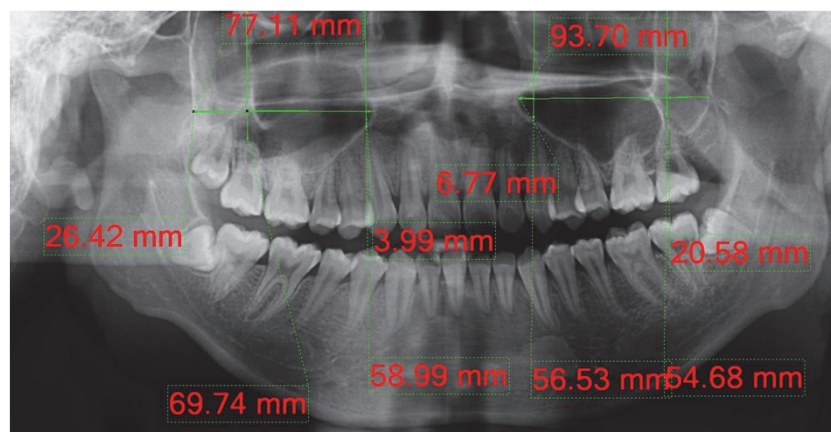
Measurement of the maxillary sinus using panoramic X-ray, mesial aspects of the maxillary sinus going toward the anterior region sextant. (Teeth number 12 and 22)
